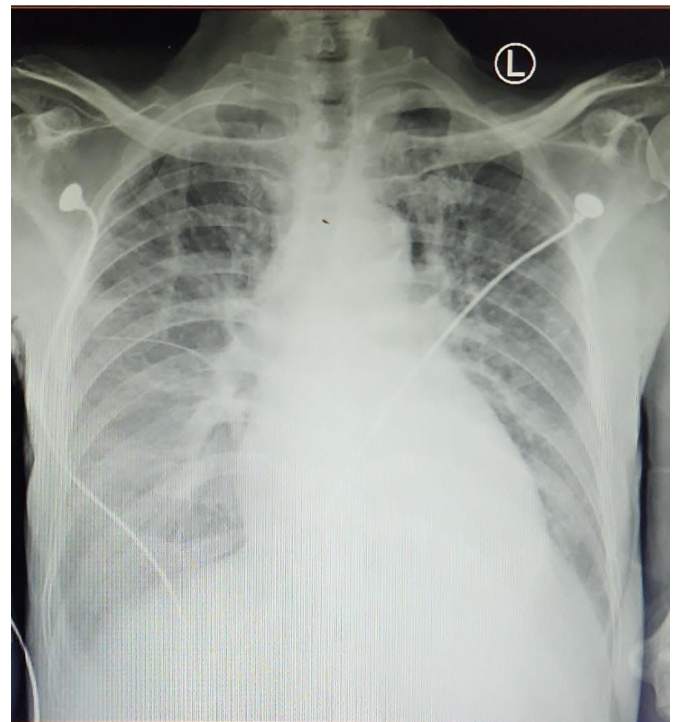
Thoracic antero-posterior (AP) X-ray imaging showed cardiomegaly, congestive pulmonum and pneumonia.
